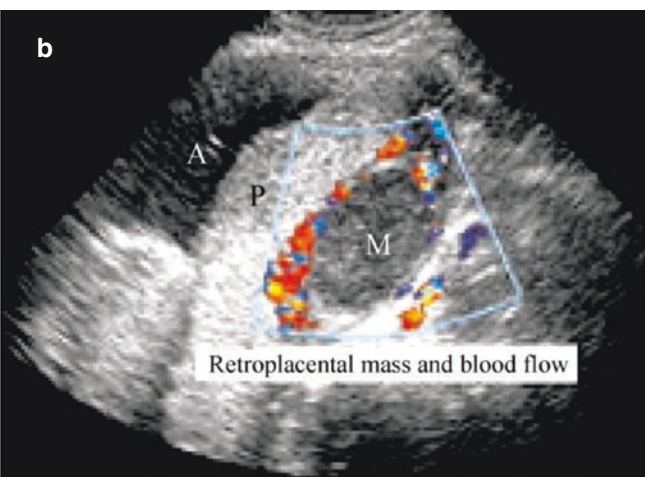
Myoma of uterus. (a, b). The patient is 30 years old and at 28 weeks of pregnancy. Sonogram shows solid hypoechoic mass between the posterior placenta and the muscle wall, with a conspicuous boundary and surrounding blood flow. M represents the myoma
